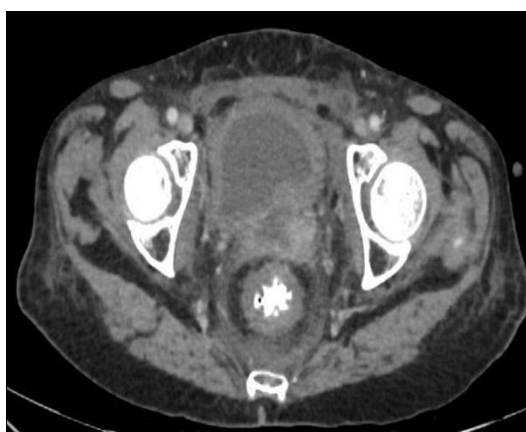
Axial CT image showing pelvis
